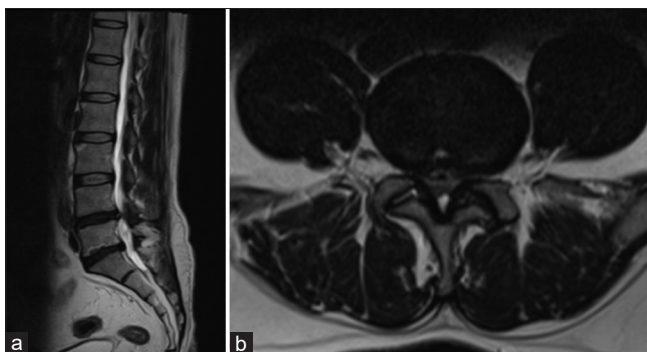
(a) Sagittal magnetic resonance images of the 45-year-old female showing mild disc bulges in L4-5 and L5-S1 with mild compression of the nerve root right more than the left at L4-5 level (b) Axial magnetic resonance images of the 45-year-old female showing mild disc bulges in L4-5 and L5-S1 with mild compression of the nerve root right more than the left at L4-5 level
